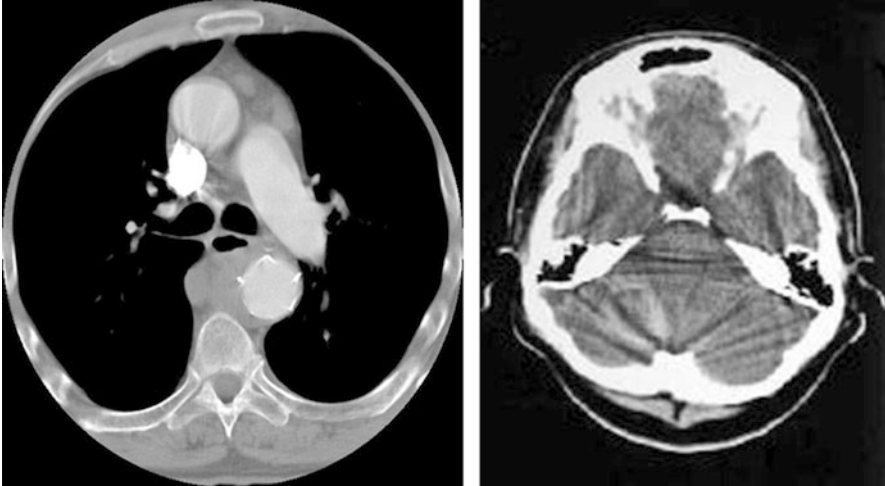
Cupping artifacts in the CT images due to beam hardening
